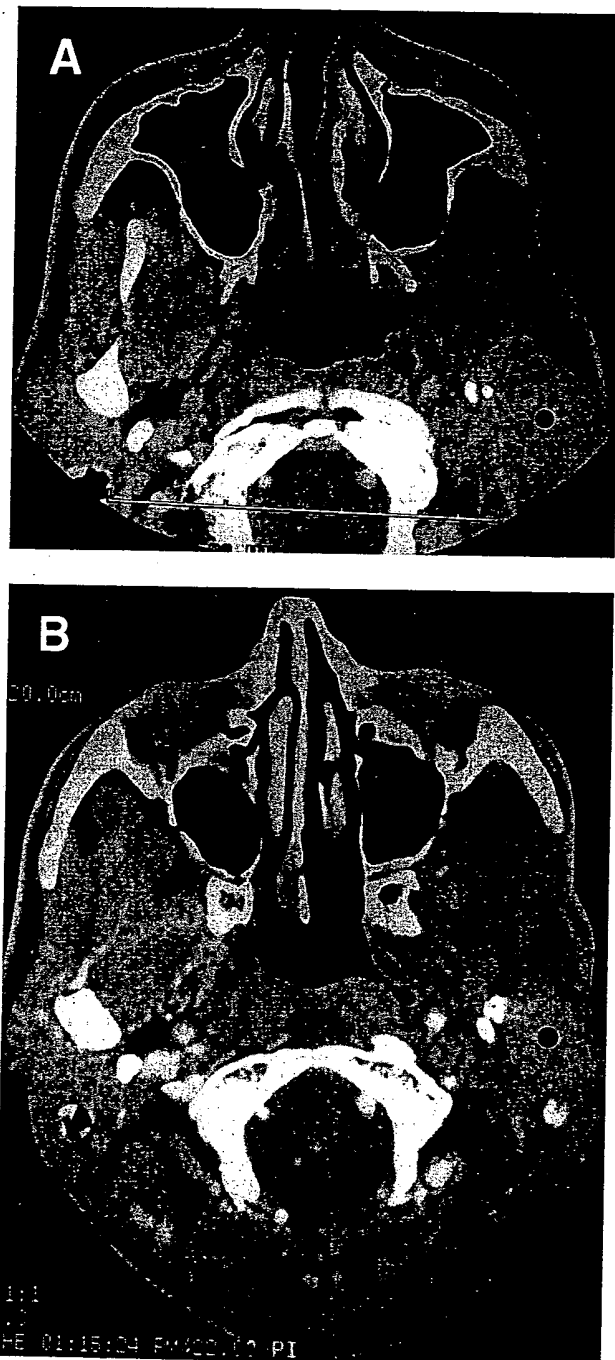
Axial post-contrast CT images (before and after 6 doses of  $10^{10}$ ) in patient 23, with recurrent HNSCC and previous hemimandibulectomy and flap reconstruction. (A) Pretreatment, postoperative distortion and enhancing tumor in the left condylar fossa/subtemporal region (dot). (B) Posttreatment, > 50% tumor reduction (dot).
